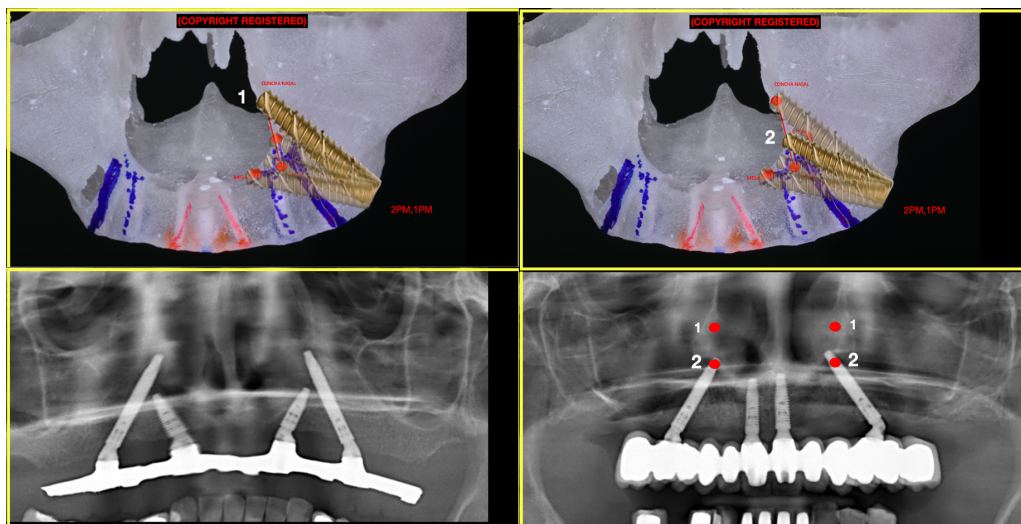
Arrangement of points 1 and 2 in the surgical planning and on the x-ray
